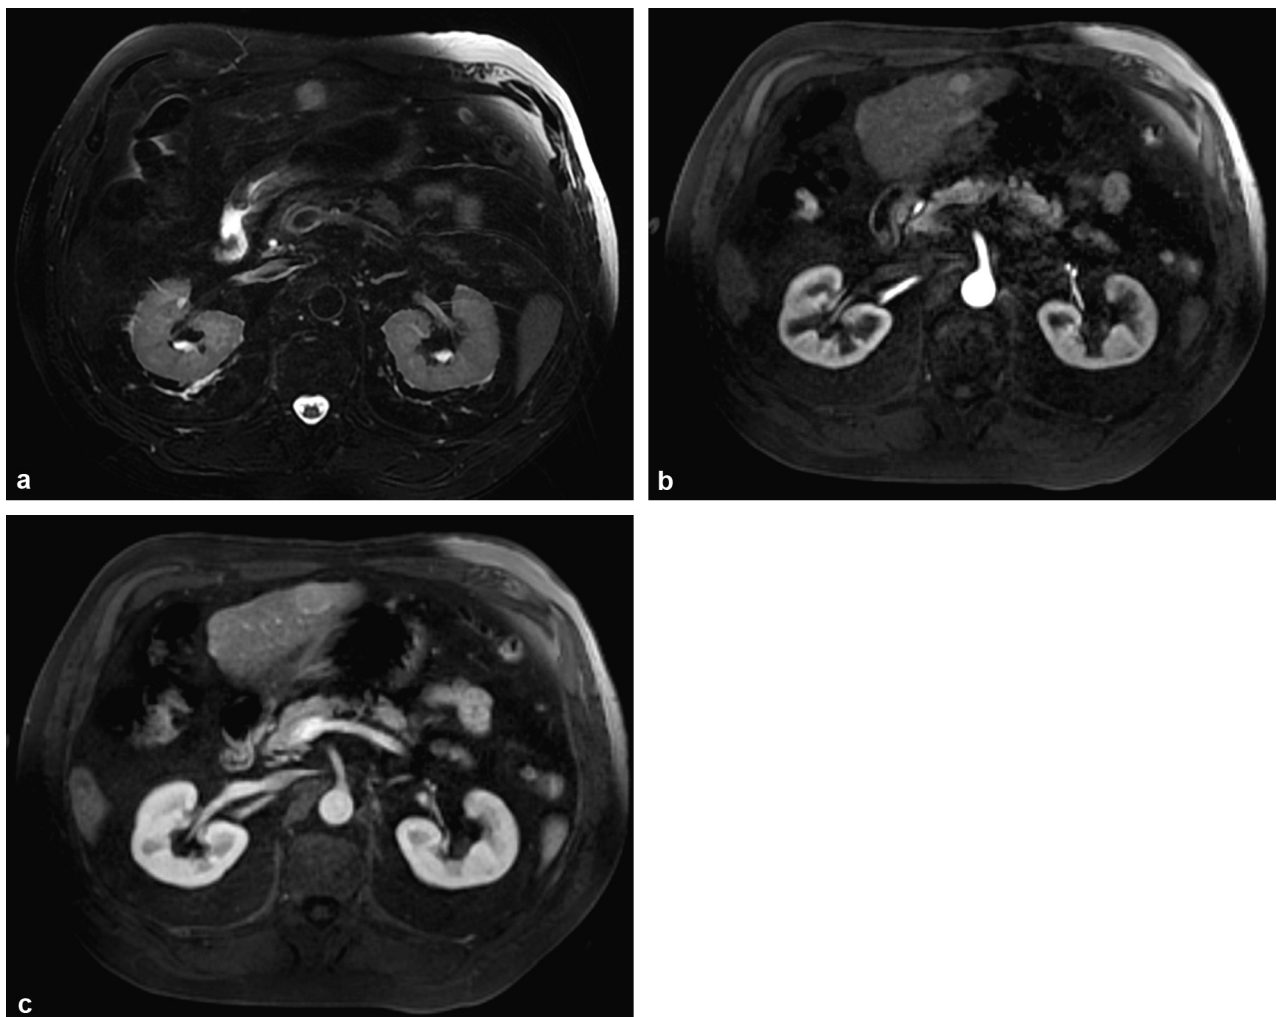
T2-weighted sequence with fat saturation (a), T1-weighted sequence with fat saturation after gadolinium injection and acquisition in the arterial (b) and portal (c) phases.
